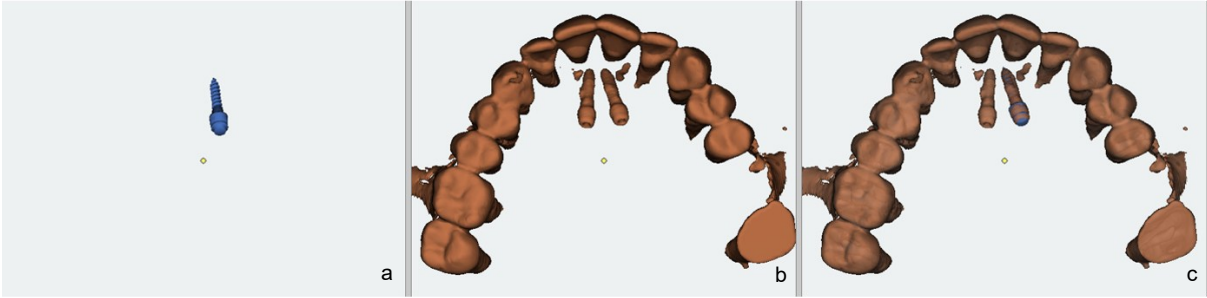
Superimposition (c) of virtual OMI (a) into the CBCT dataset (b)
